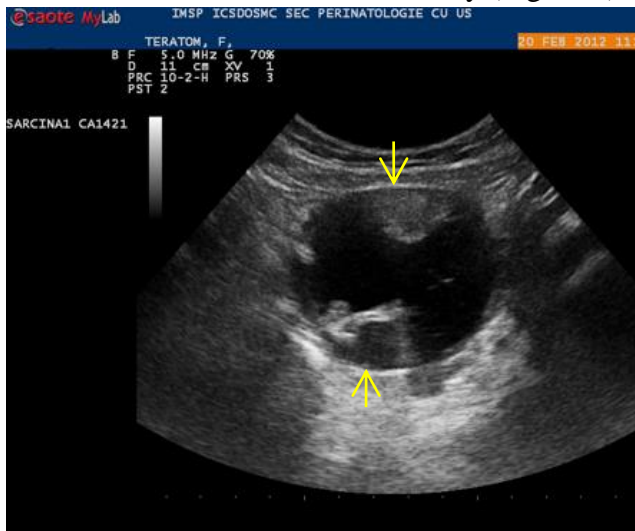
Ultrasound: mature teratoma of the left ovary, Rokitansky node (→)
